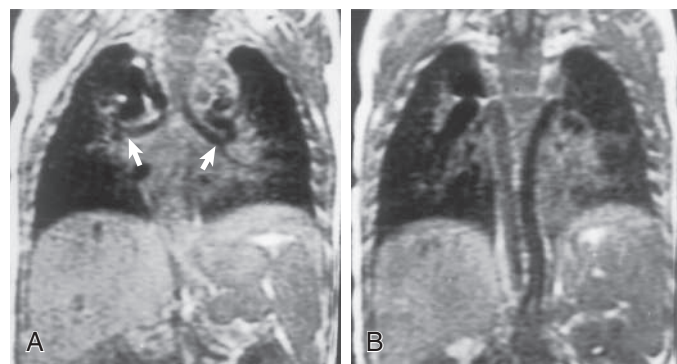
A, Coronal T1-weighted MRI of a patient with heterotaxy syndrome (polysplenia) demonstrates a bilateral hyparterial bronchial branching pattern (arrows) and left upper quadrant splenic tissue. B, More posterior coronal T1-weighted MRI shows left azygos-hemiazygos continuation to the left superior vena cava and right thoracic aorta. (From Applegate KE, Goske MJ, Pierce G, Murphy D. *Situs revisited: imaging of the heterotaxy syndrome*. *Radiographics*. 1999;19:837–852, Fig. 4.)
